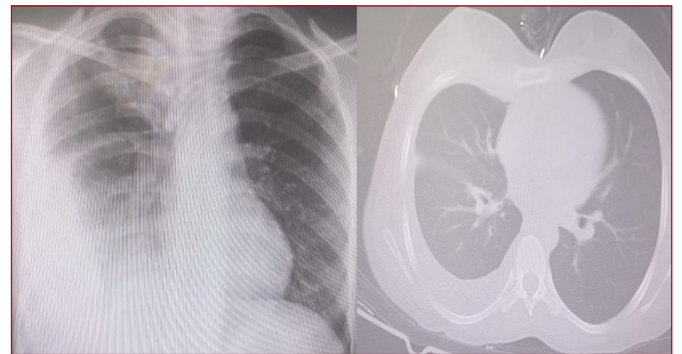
X-Ray and Tomography Image of the Case
